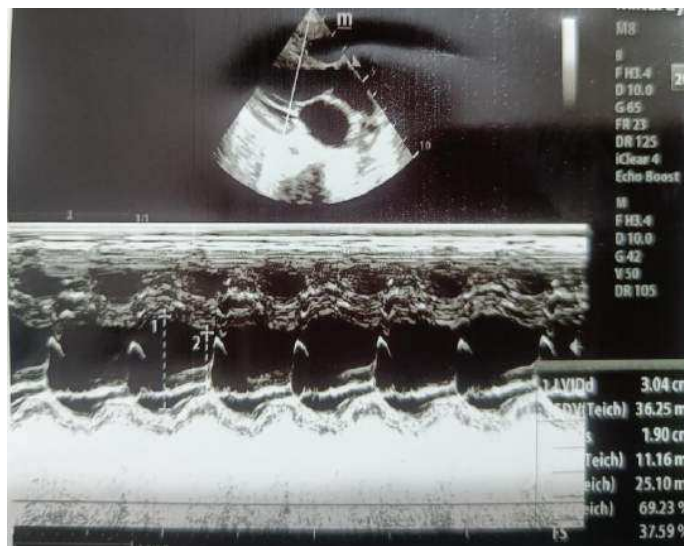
Echocardiography showing fractional shortening of 37.59% and ejection fraction of 69.23% with good biventricular function in a patient of the ventricular septal defect.
